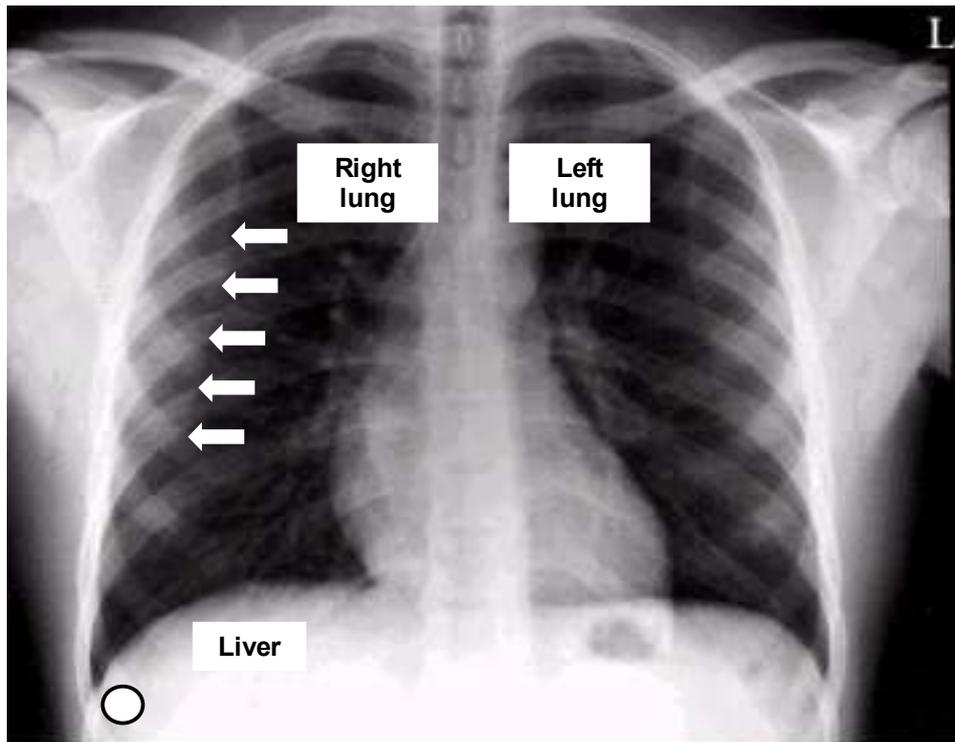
A normal X-ray of the chest showing the vertical inner edge of the right scapula and the liver (adapted from Dick, 2000 ; © BMJ).
